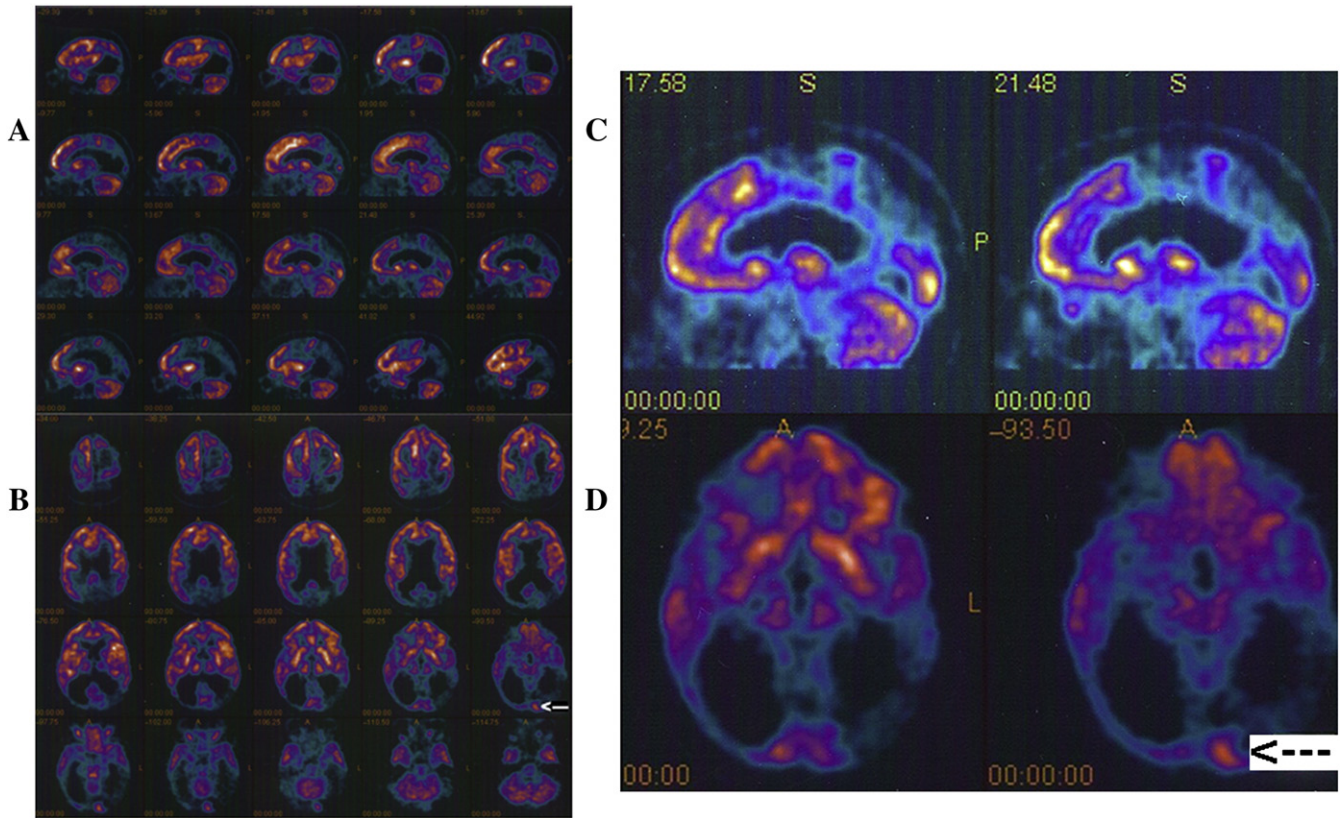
Case 2. Cerebral PET study performed 12-months after commencing GH treatment and visual stimulation. The patient was given 250 Mbq F18-FDG, iv, and 45 min later she was stimulated with repetitive white light flashes for 15 min (similar to those used for daily visual stimulation). A: sagittal sections. B: transversal sections. C: magnification of two images shown in A. D: magnification of two images shown in B. Black arrow signals metabolic activity in the left occipital lobe at the level of cuneus/calcarine fissure.
